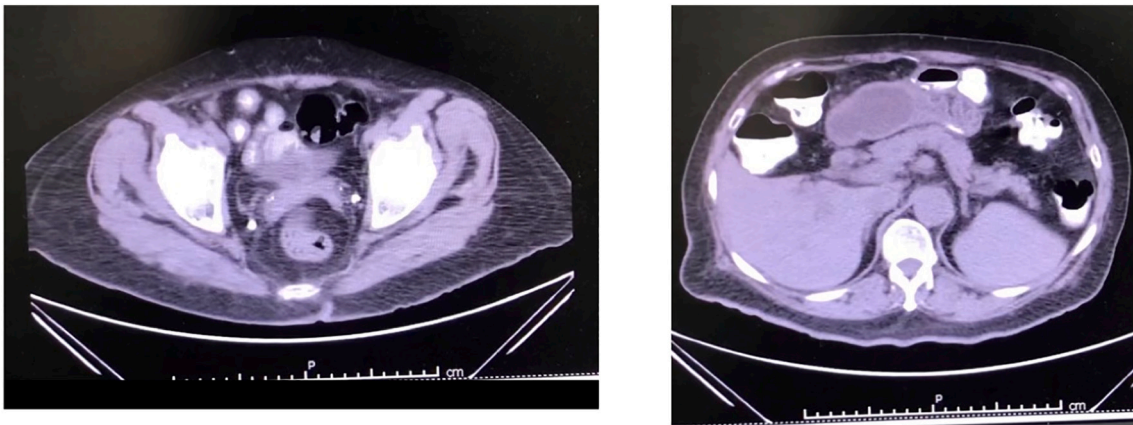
CT scan showing inflammation on the small bowel.
